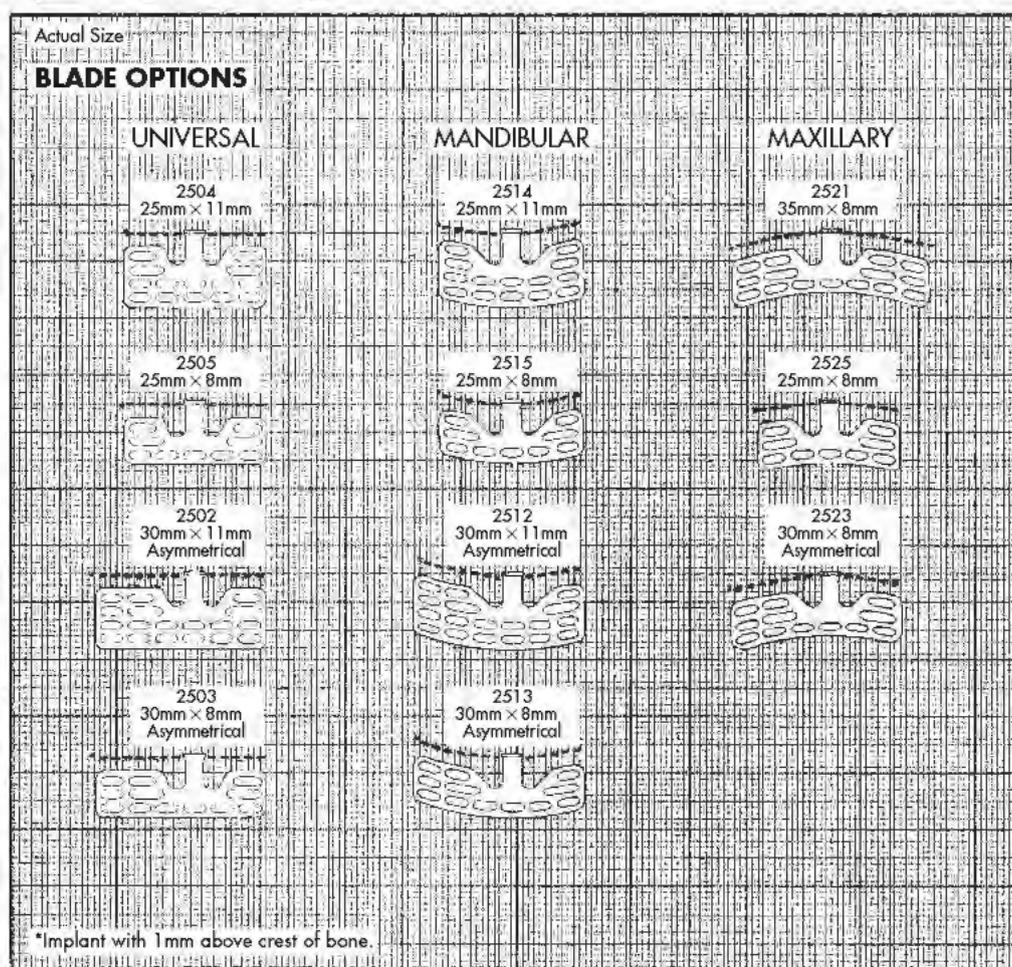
Table 4-3 presents a list of current blade and plate-form manufacturers. Most of these companies produce templates designed to be held against radiographs. A and B, Holding the template against a radiograph allows the surgeon to choose the design with the most favorable size and configuration. Templates with 25% enlargements are available for use with panoramic radiographs; however, this is not a reliable technique for final selection. (A Courtesy Steri-Oss, Yorba Linda, Calif.; B Courtesy Ultimatics, Springdale, Ark.)
